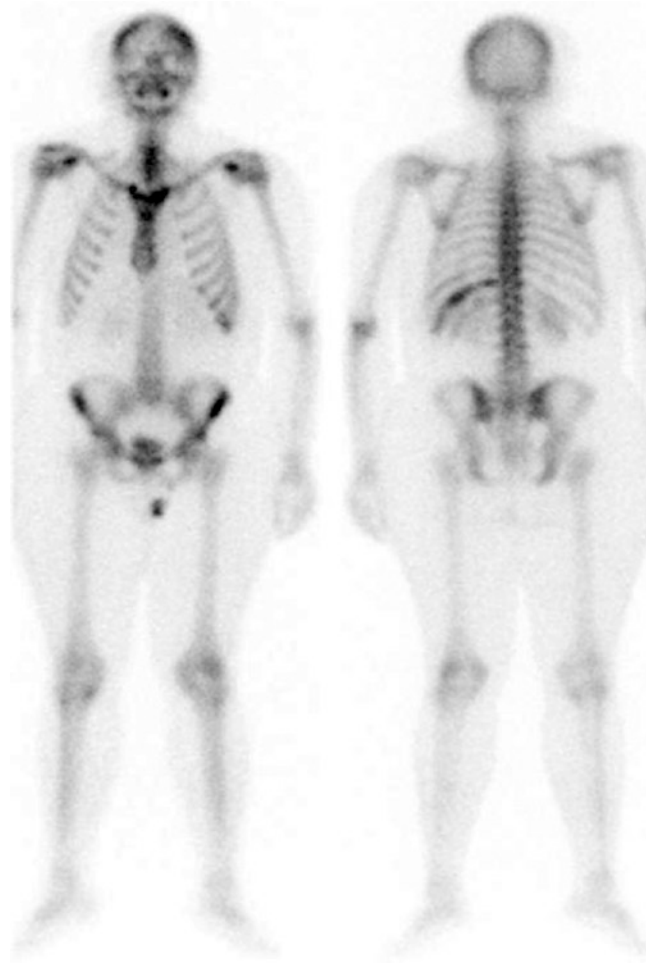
Planar whole-body scintigraphy with ^{99m}Tc -HDP in a patient with newly diagnosed osteosarcoma confined to the left 11th rib, better imaged in the posterior view. The scintigraphic pattern per se does not have distinctive features allowing a differential diagnosis versus other bone diseases (reproduced with permission from: Volterrani D, Erba PA, Mariani G, Eds. *Fondamenti di Medicina Nucleare – Tecniche e Applicazioni*. Milan: Springer Italy; 2010)
